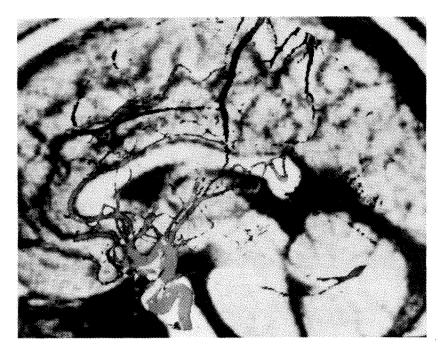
Combined image of MRI and DSA information.
